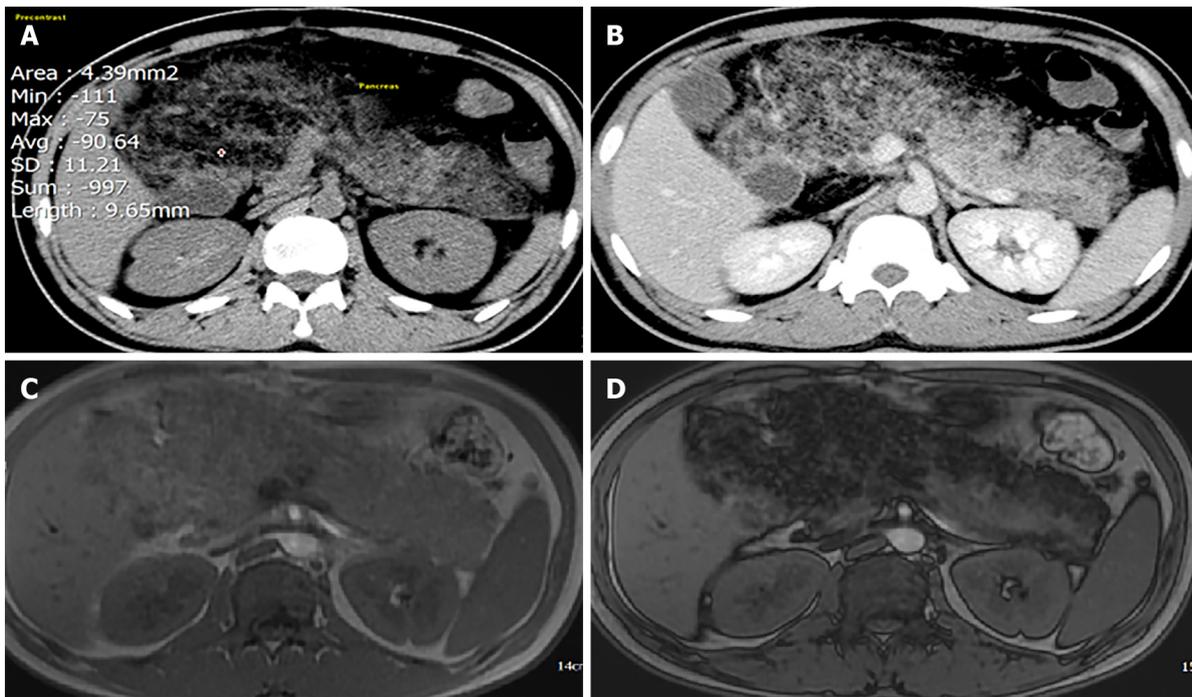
Computed tomography (CT) and magnetic resonance imaging (MRI). A: Plain CT: density of the pancreatic parenchyma was uniformly decreased to the same level as that of the surrounding fatty tissue (attenuation value = 90.64 HU); B: Contrast-enhanced CT: Pancreatic parenchyma was absent, completely replaced by fat; C and D: MRI of the pancreas. In- and out-phase MRI respectively show a typical global (C) hyperintensity; and (D) fat suppression.
